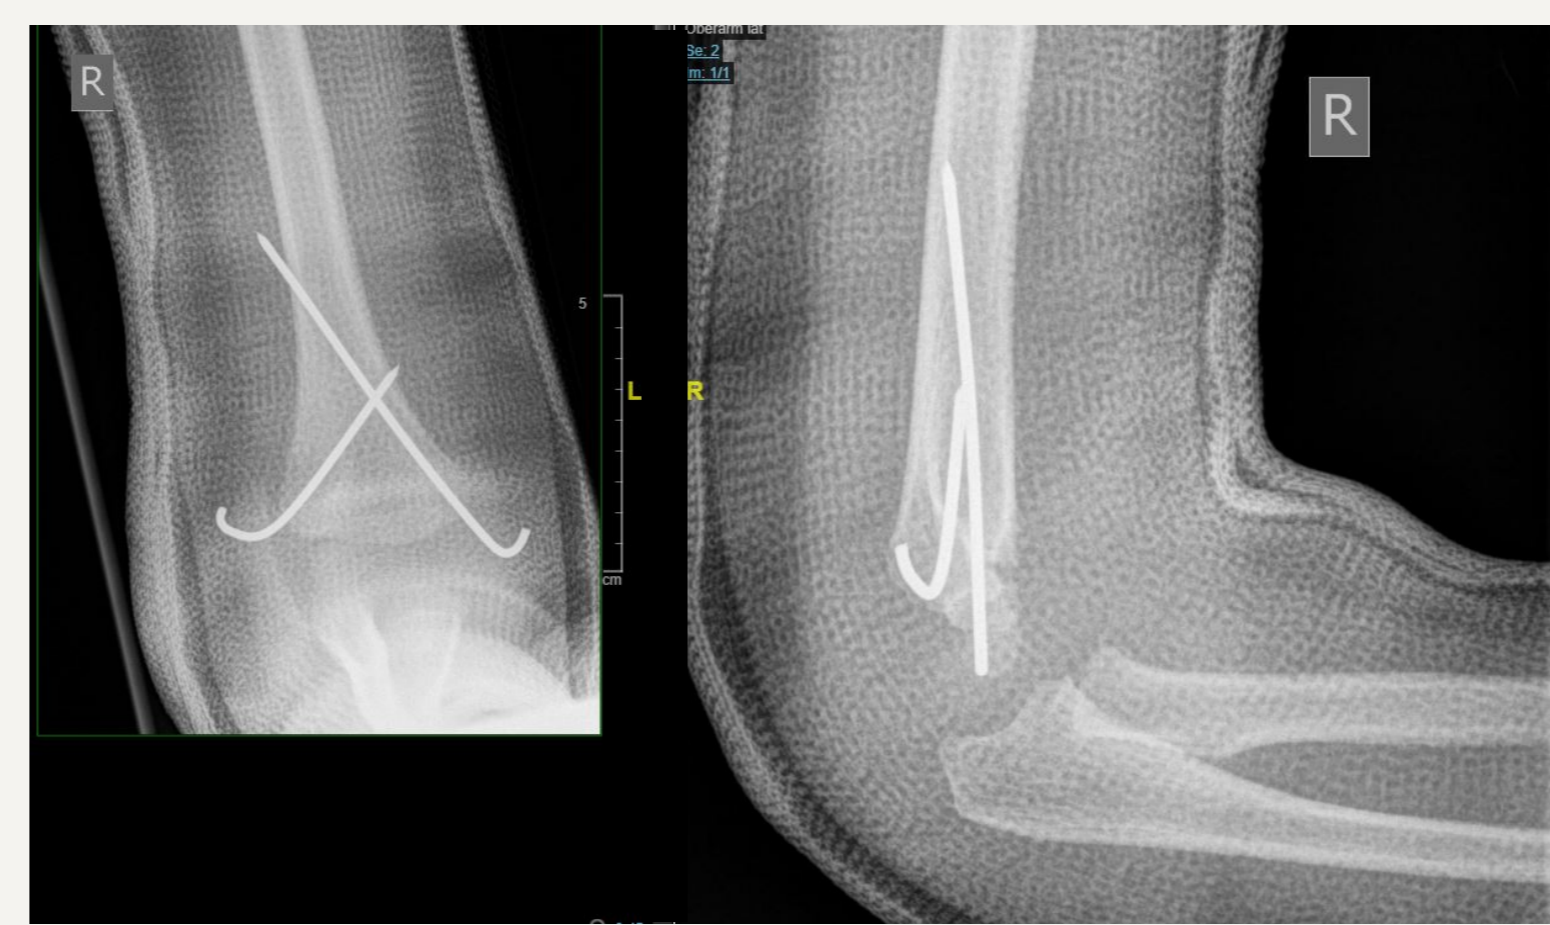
ap/lateral radiograph, 1 week postoperatively
